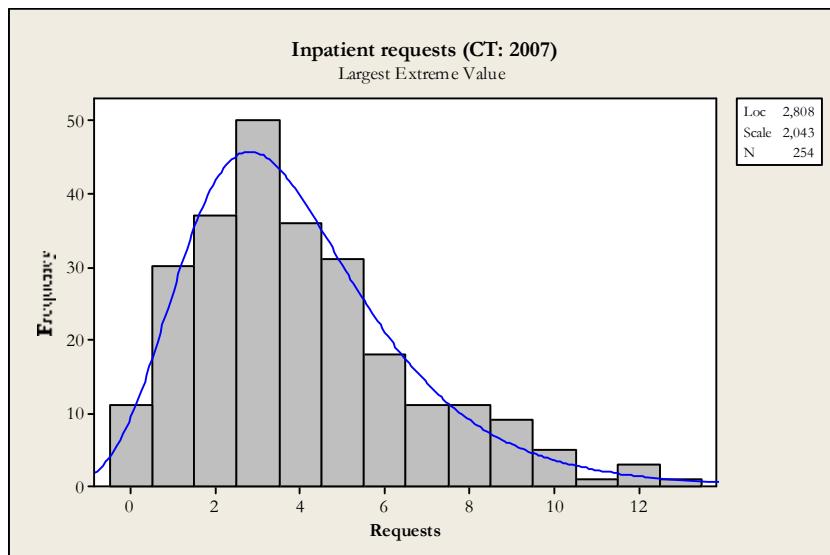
Fitted distribution for inpatient CT requests (RIS: 2007). Distribution: max. extreme (Location: 2,81; Scale: 2,04).
